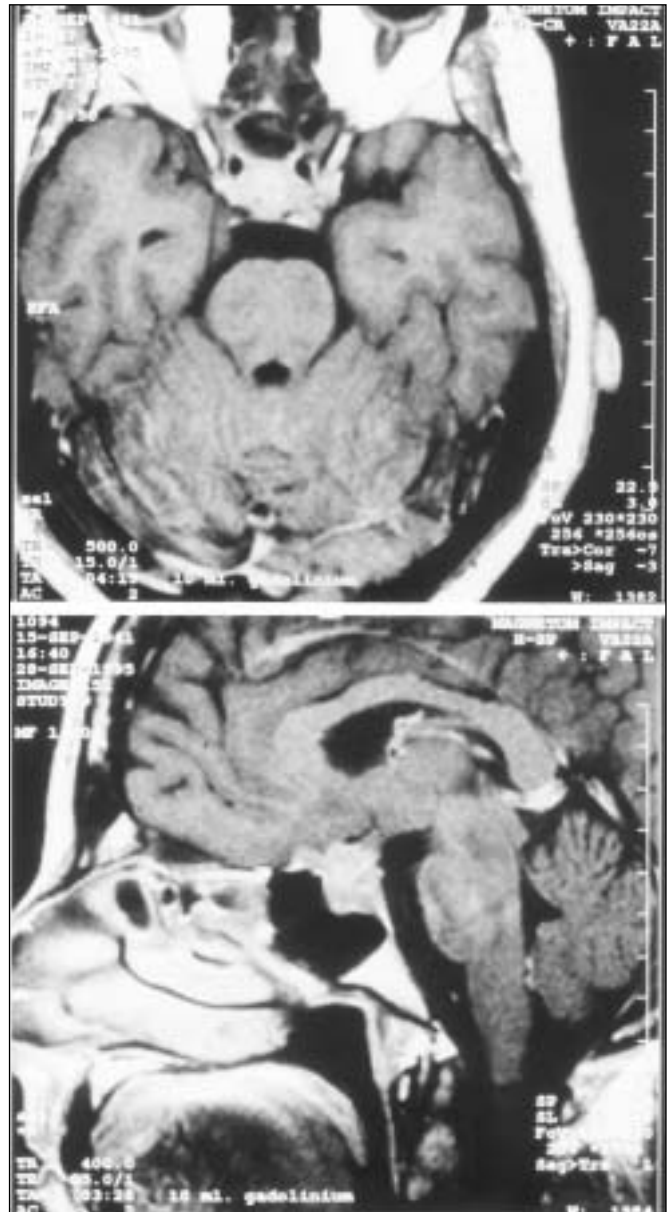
Magnetic resonance imaging (T1-weighted sequences, gadolinium-enhanced): a lobulated mass in the pituitary fossa, bulging upward, is visible on axial (top) and sagittal (bottom) views.
